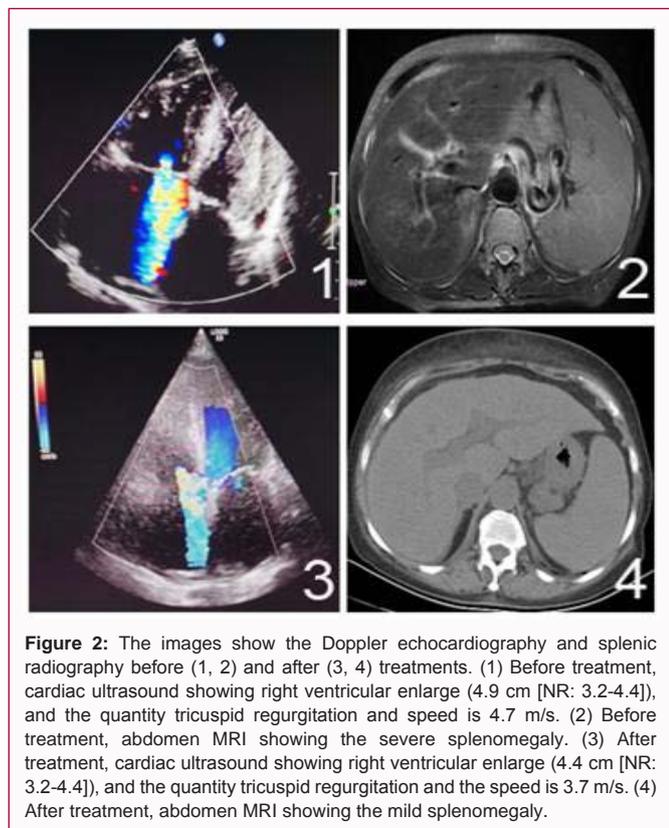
The images show the Doppler echocardiography and splenic radiography before (1, 2) and after (3, 4) treatments. (1) Before treatment, cardiac ultrasound showing right ventricular enlarge (4.9 cm [NR: 3.2-4.4]), and the quantity tricuspid regurgitation and speed is 4.7 m/s. (2) Before treatment, abdomen MRI showing the severe splenomegaly. (3) After treatment, cardiac ultrasound showing right ventricular enlarge (4.4 cm [NR: 3.2-4.4]), and the quantity tricuspid regurgitation and the speed is 3.7 m/s. (4) After treatment, abdomen MRI showing the mild splenomegaly.
